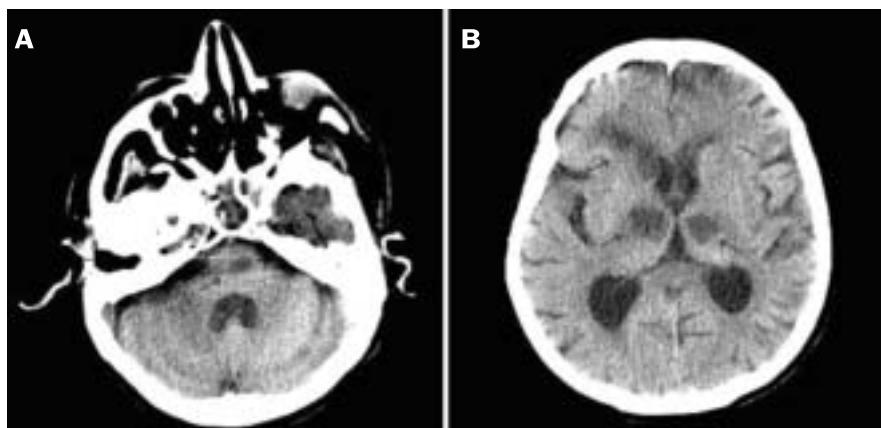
CT of the brain showing axial cuts without contrast injection. [A] Image at the fourth ventricle and the level of the pons showing infarct, and [B] image at the level of the third ventricle demonstrates bilateral infarcts in the thalamus and an infarct in the right frontal lobe. A CT performed 10 days earlier was normal.
